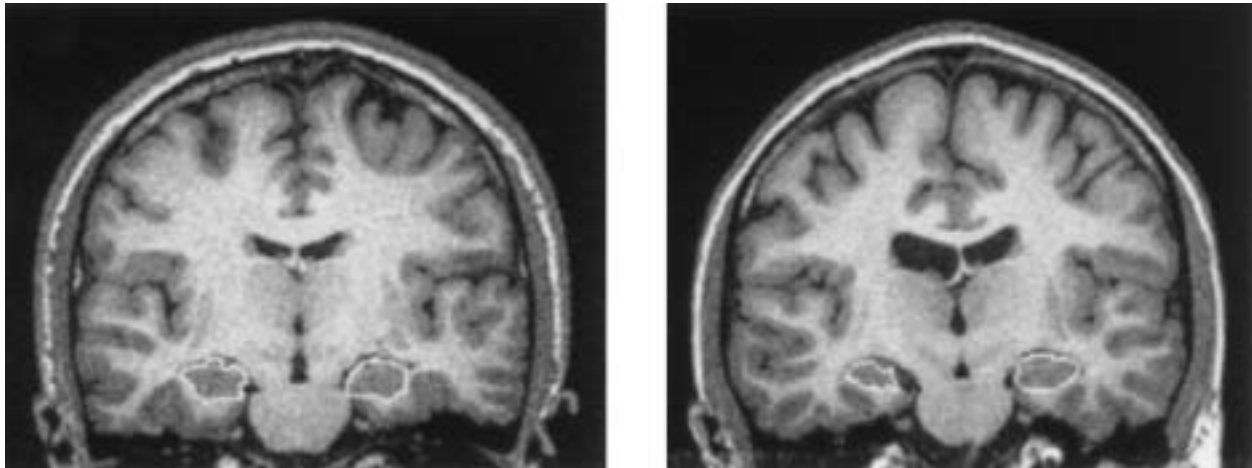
Comparative coronal MR images showing the hippocampi in patients with perinatal asphyxia (right side) and their matched control. In each image, left side corresponds to the right hemisphere, and right side corresponds to the left hemisphere.
